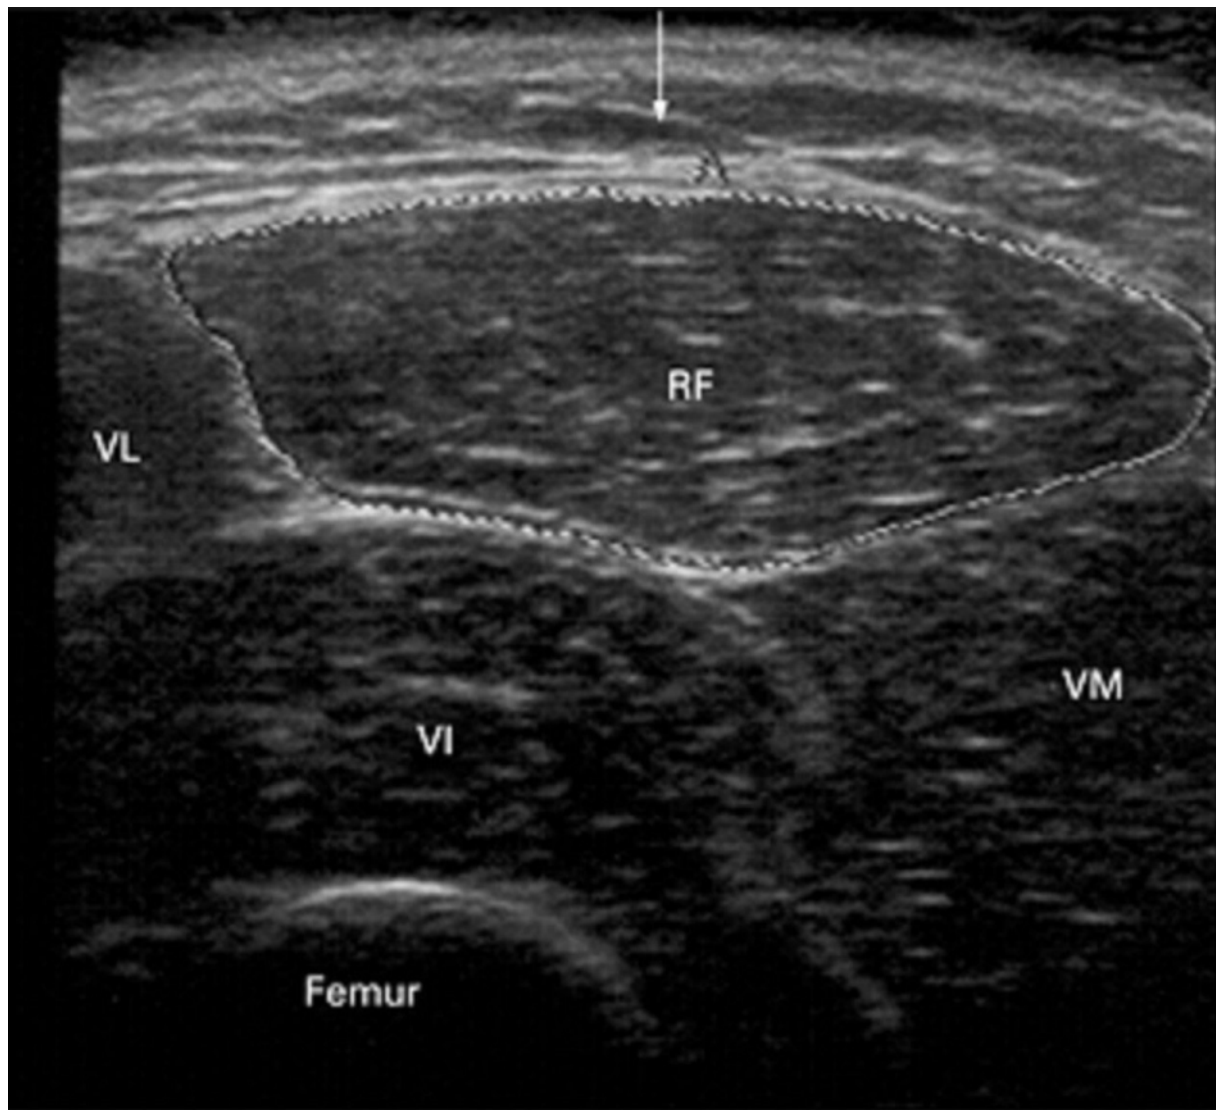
Ultrasound of the quadriceps
